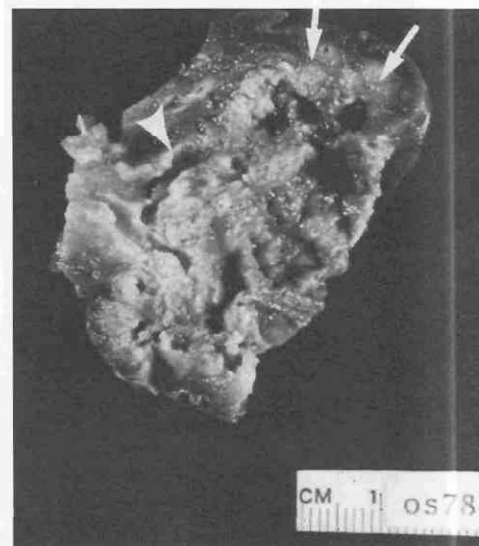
Pathology of tracheolaryngeal papillomatosis. A large cavitary space (arrows) is lined with verrucous papillomatous tissue. The adjacent bronchus is also involved (arrow-head). Papilloma fragments lodge in distal airways, where they grow along the terminal air spaces. Cavitary spaces form when papillomatous tissues cause bronchiolar obstruction or when papillomatous tumor masses necrose. (From Kuhlman JE, Reyes BL, Hruban RH, et al: Abnormal air-filled spaces in the lung. *Radiographics* 13:47-75, 1993.)
